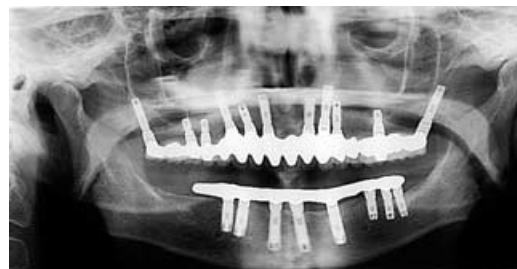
Panoramic radiograph with definitive prostheses in place (2005).
